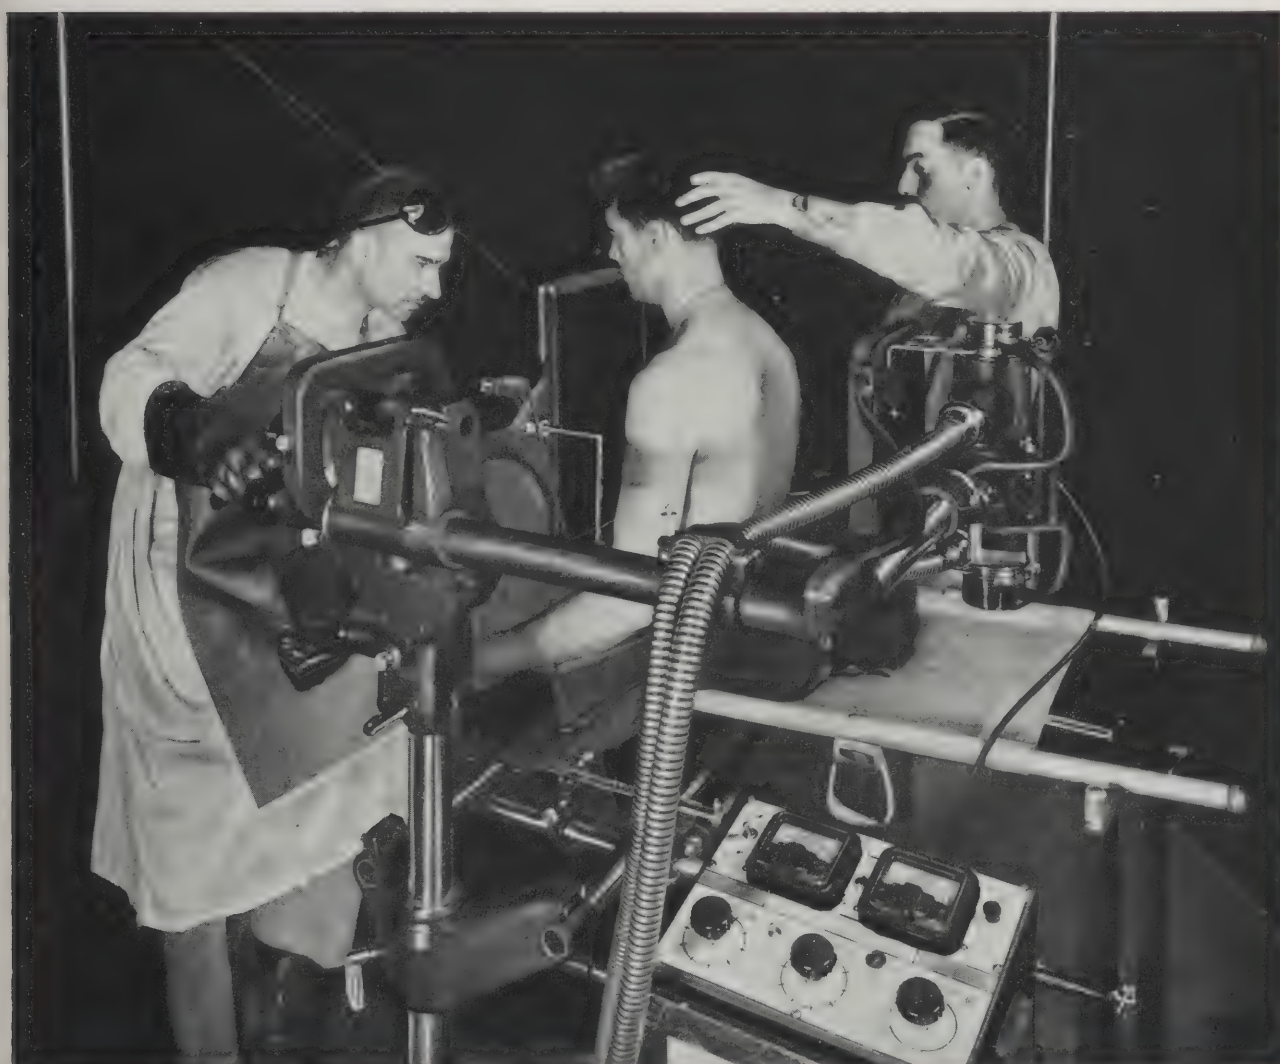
Item 96085 assembled with Item 96145 and in position for sitting roentgenoscopy.
